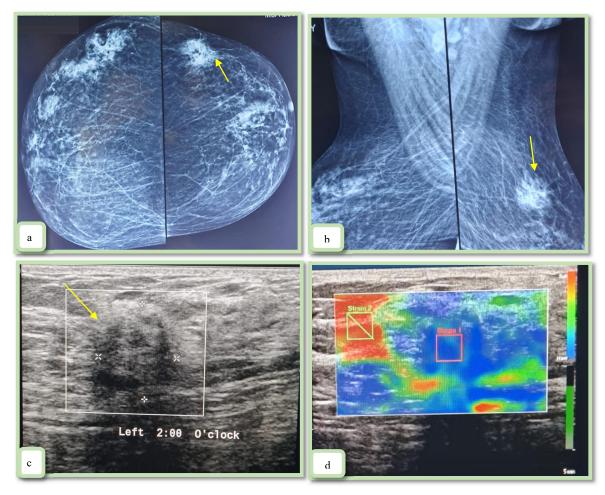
56-year-old obese post-menopausal female patient complained of a left breast lump. (a & b) Bilateral digital mammography, craino-caudal and medio-lateral oplique views (CC & MLO) respectively, showed increased fibro-glandular condensation suggestive of mild fibroadenosis (ACR b), an irregular opacity at left upper breast (yellow arrows). (c)Transverse B- mode of breast ultrasonography, revealed an irregular hypoechoic soft tissue lesion was seen at the left 2 O'clock position (yellow arrows). (d) Elastography sonography examination revealed (transverse view), showed mixed green and blue colour with predominate of the blue colour (red box) breast lesion, compared to green square of normal breast tissue, denoting hard consistency of the breast lesion with high strain ratio (SR) 2.6, malignant breast lesion.
